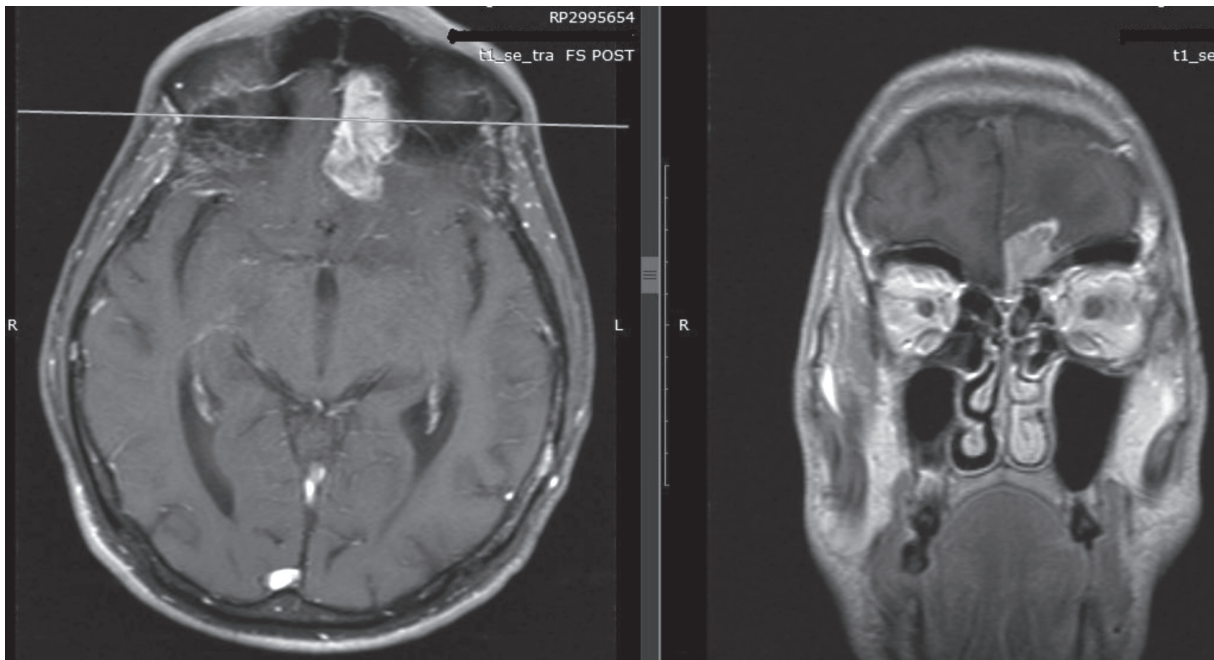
Preoperative (before the first surgery) Contrast-enhancing MRI; [on left: T1-weighted axial image, on right: T1-weighted coronal image] demonstrated heterogeneous contrast-enhanced signal tumor that surrounded by edema in the left parietal lobe.
